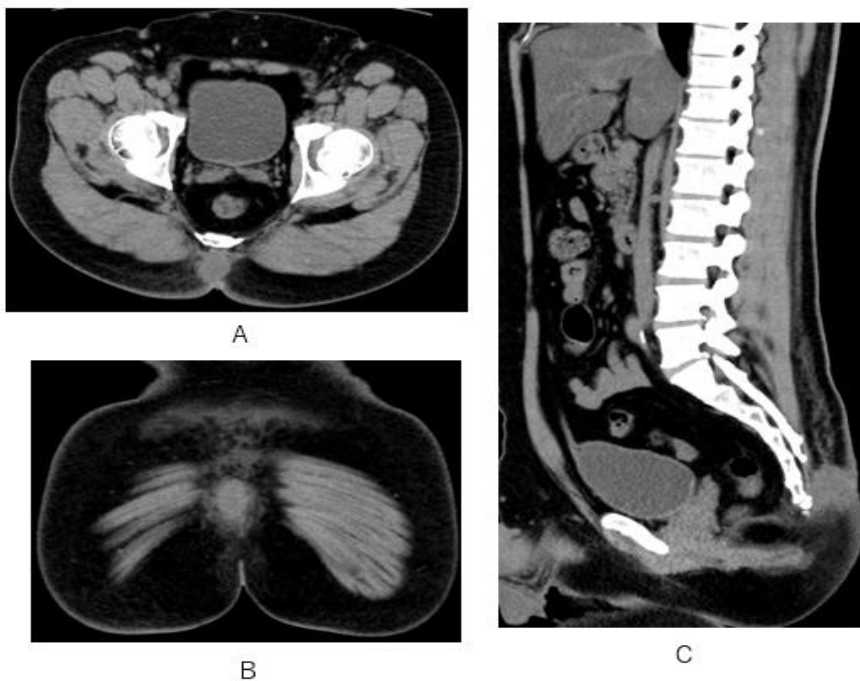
A nodule with soft tissue attenuation is depicted a lesion at subcutaneous midline behind coccyx bone on axial (A), coronal (B) and sagittal (C) CT.
